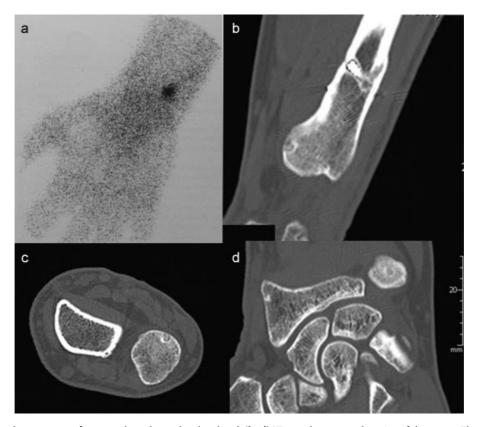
(a) Bone scan shows an area of increased uptake on the ulnar head. (b-d)CT scan shows exact location of the tumor. The osteoid osteoma is located on the articular surface of the ulnar head, easily accessible in supination of the forearm.
